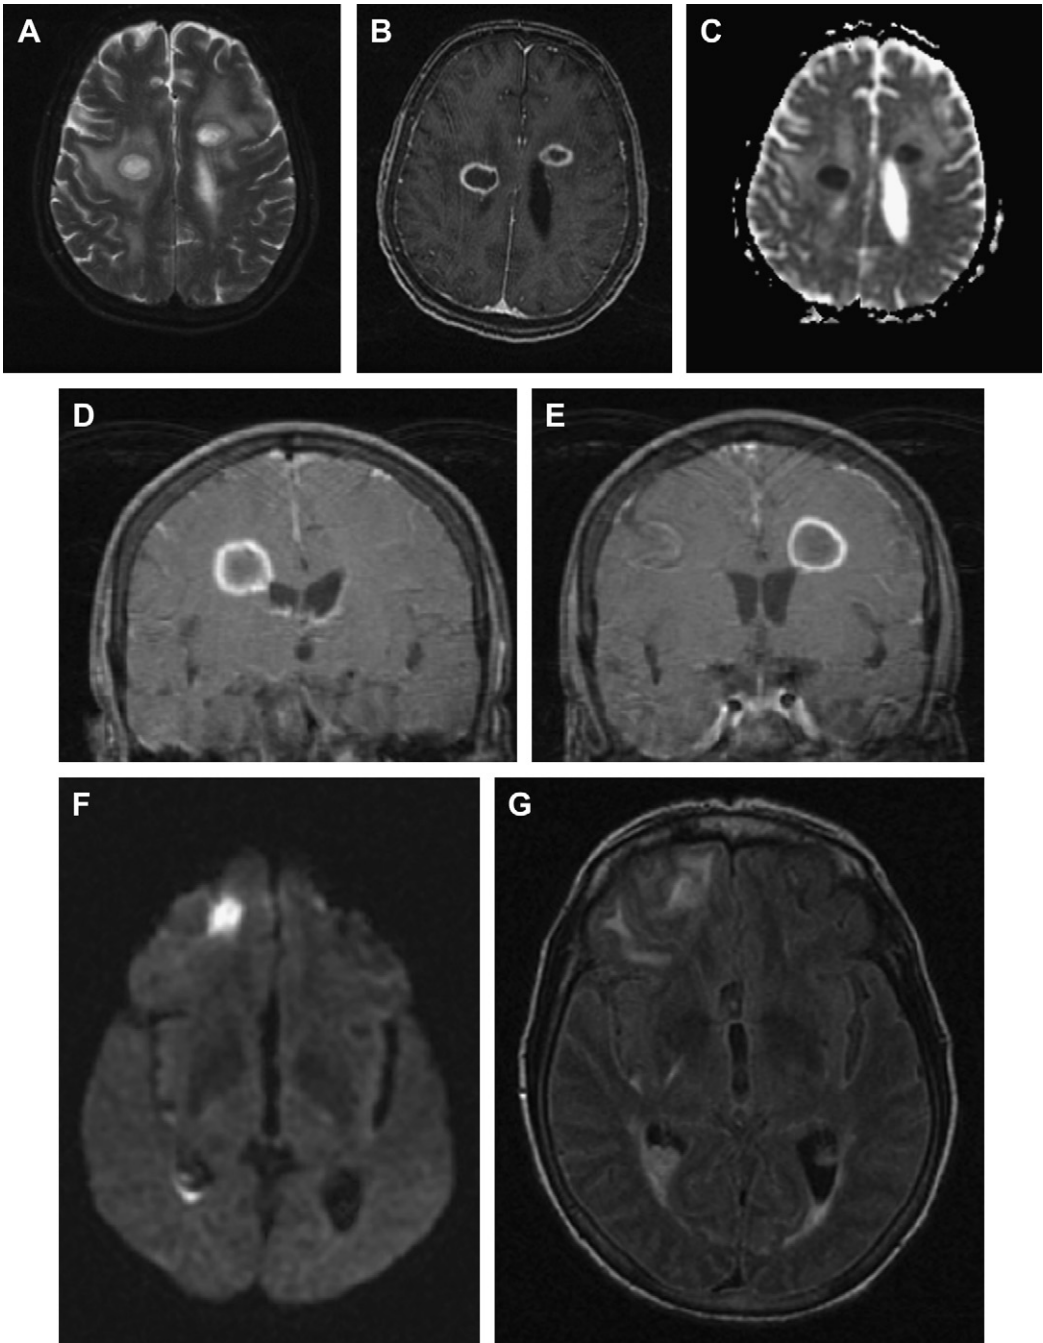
A 68-year-old woman presented with altered mental status. (A–C) T2, T1 postcontrast, and ADC maps demonstrate multiple bilateral abscesses with central T2 hyperintense signal and surrounding T2 hypointense signal, peripheral smooth rim enhancement, and reduced ADC values. There is characteristic thinning of the capsules along the ventricular margins. (D, E) Coronal T1 postcontrast images redemonstrate thinning along the medial margin of the abscess capsules where they communicate with the ventricular system. There is associated abnormal ependymal enhancement (*white arrow*). (F, G) Diffusion-weighted sequence and fluid-attenuated inversion recovery (FLAIR) sequence confirm intraventricular rupture and ventriculitis, with debris layering dependently in the ventricular system. (Courtesy of William Delfyett, MD, University of Pittsburgh.)
